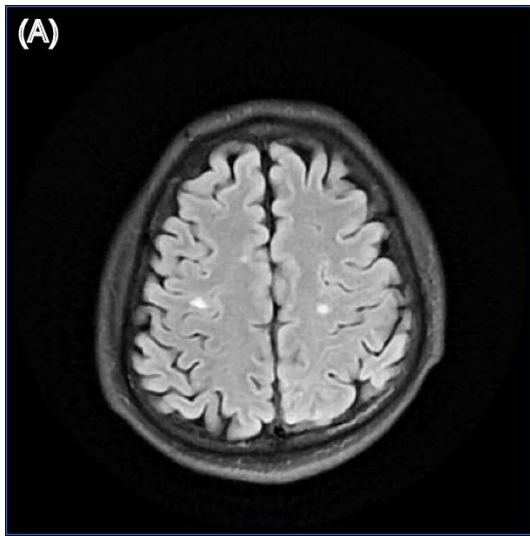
Structural brain MRI images of patient 25. (A) T2-weighted fluid-attenuated inversion recovery (T2-FLAIR) image; (B) Gadolinium-enhanced T1-weighted (Gd-T1w) image.
